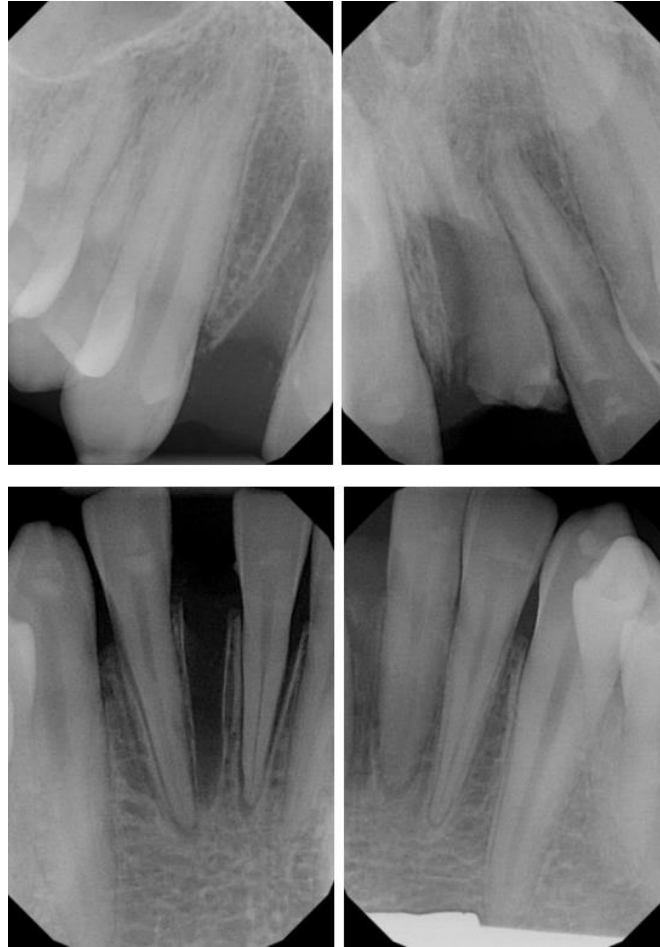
4 x long cone periapical (LCPA) radiographs, which were taken by referring GDP on day on injury revealed: empty sockets at the 11 and 41 positions; crown-root fracture 21 tooth; and (with respect to socket outline) extrusion of 42 and 31 teeth. 11 tooth not shown.
